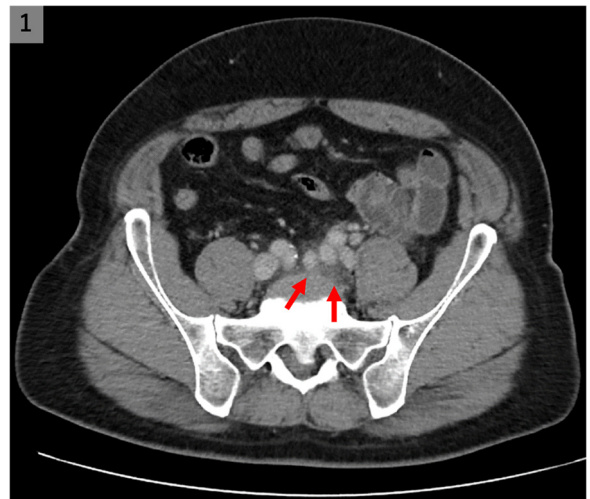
Non-contrast abdominal CT showed paravertebral cellulitis without abscess formations (arrows).
